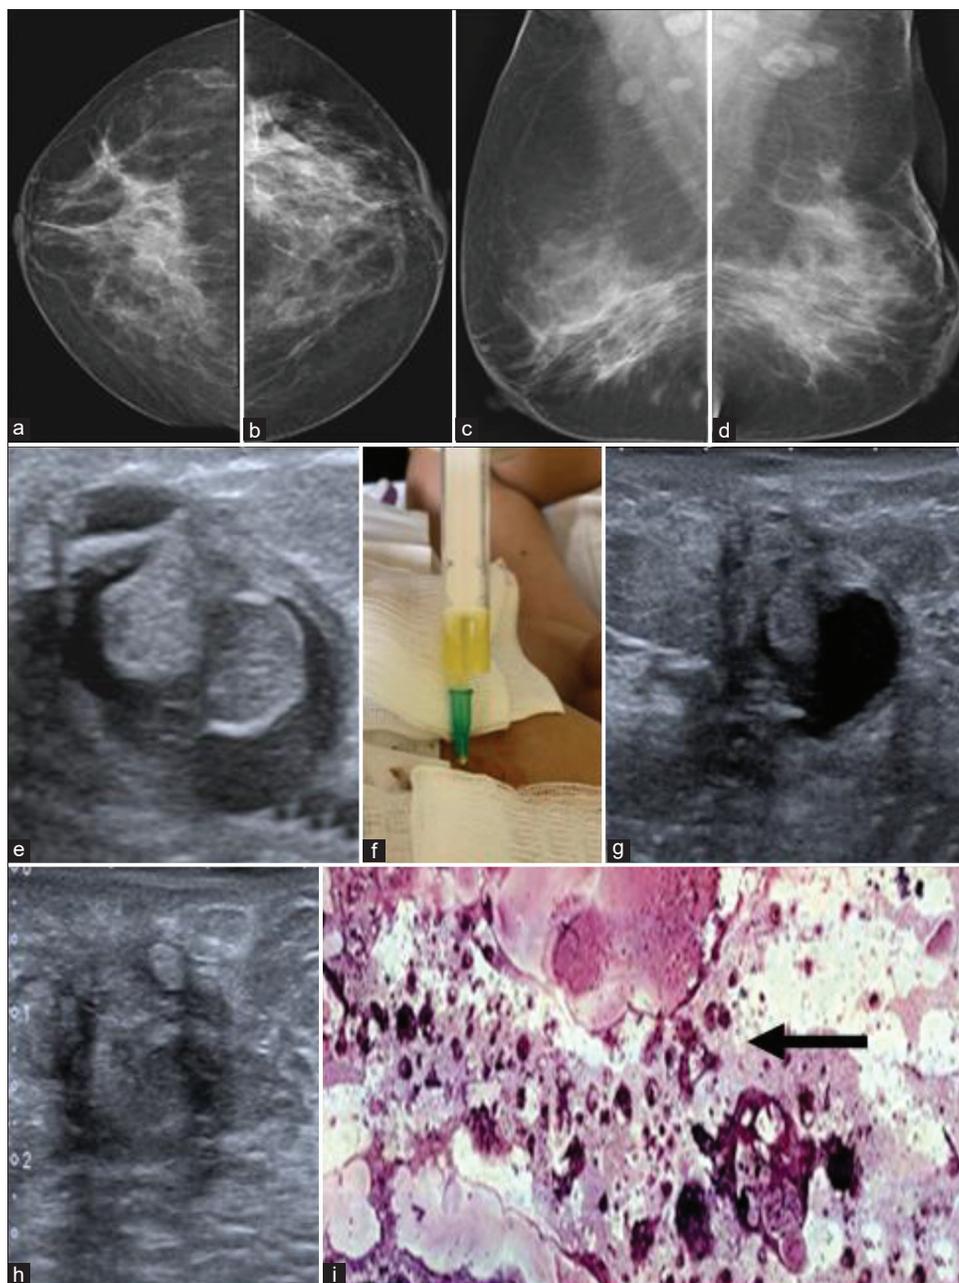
A 46-year-old female post-operative case of phyllodes tumor – 18 months, came for a routine check-up with no specific complaints. X-ray mammogram (a and c) CC and MLO view of the right breast shows no abnormality and (b and d) CC and MLO view of the left breast shows architectural distortion involving the upper outer quadrant with adjacent skin retraction (e) ultrasound image shows an oval parallel oriented circumscribed anechoic mass with few hyperechoic areas within (g) shows image of fine-needle aspiration of the mass with thick yellow oily fluid being aspirated. (h) Post-aspiration image showing complete resolution of the cystic mass. (i) Cytology: H & E: Showing fat necrosis (Black Arrow) $\times 200$
